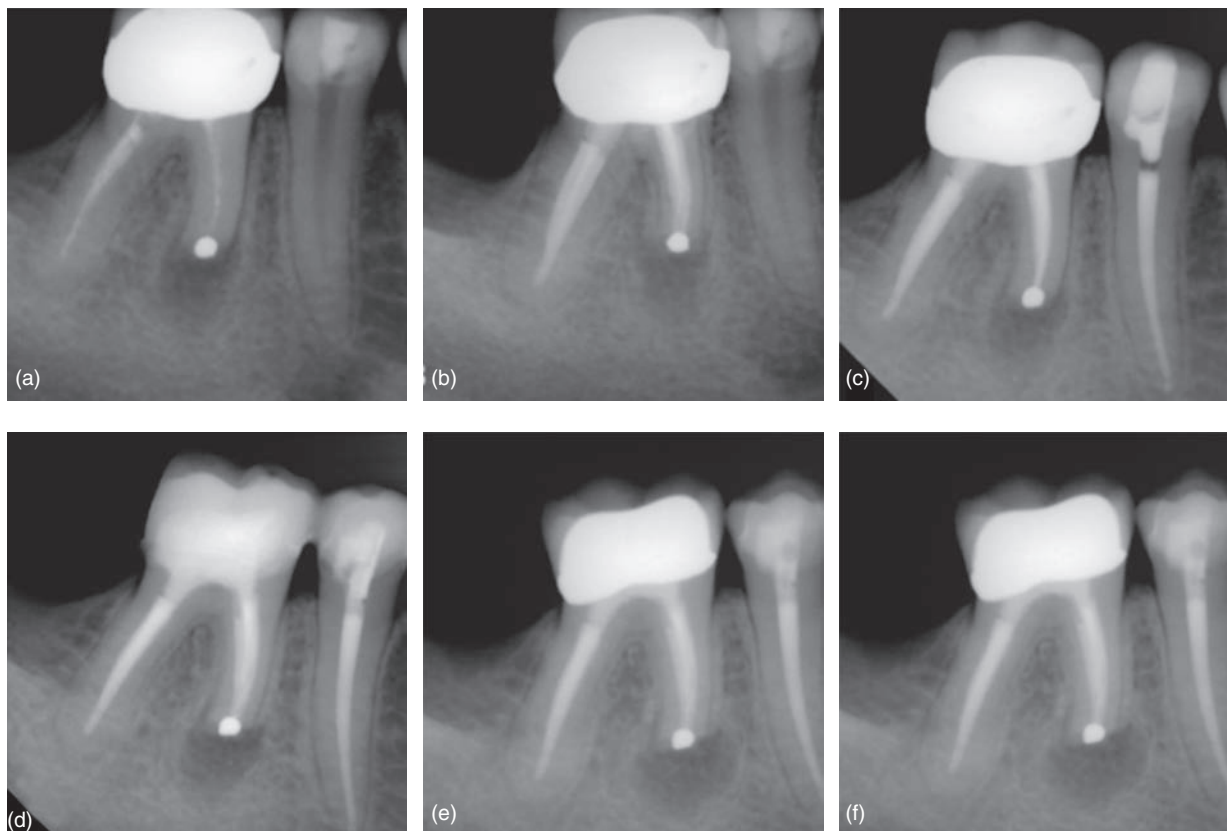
Amalgam placed as a root end filling material on a previous failed surgery done with the traditional technique on tooth #30. Non-surgical retreatment was performed, but periapical lesion persisted. A second apical surgery using microsurgical technique was done and the periapical pathology was eliminated. It is obvious that the cause of the persistent periapical lesion was a long, type V isthmus. (a) Preoperative radiograph; (b) non-surgical retreatment; (c) 6 month recall radiograph; (d) 1 year recall radiograph; (e) 2 year recall radiograph showing persistence of the periapical lesion on the mesial root; (f) preoperative radiograph of the second periapical surgery.
